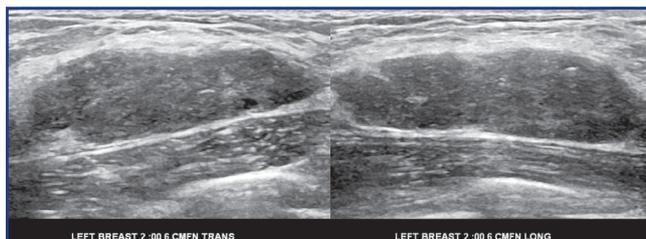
Ultrasound examination of the left mammary gland: a hypoechoic neoplasm with precise contours and heterogeneous structure
